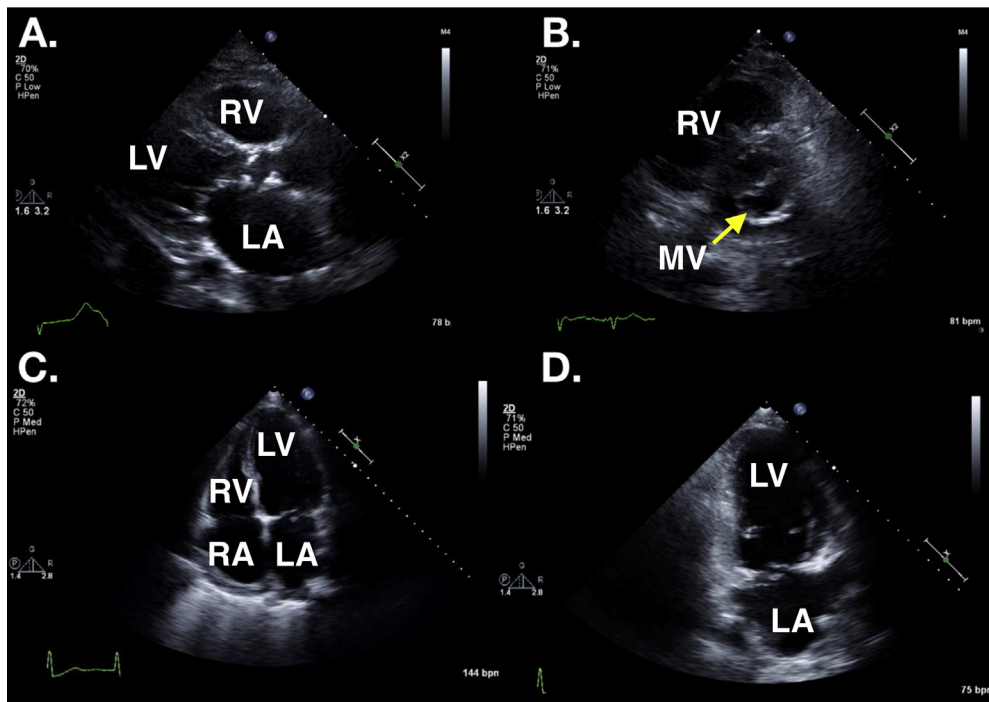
TTE views of the MV. (A) PLAX view provides visualization of the central anterior and posterior leaflet (A2/P2); for medial (A3/P3) and lateral (A1/P1) visualization the probe can be tilted toward the tricuspid valve and aortic valves, respectively. (B) PSAX view of the MV provides the characteristic “fish mouth” view of the MV and will allow for the origin of the MR jet to be determined and for planimetry of MVA (yellow arrow). (C) Apical four-chamber view allows for chamber quantification, both qualitative and quantitative assessment, of the MR as well as measurements of transvalvular gradients. (D) Apical two-chamber view of the MV allows for interrogation of the line of coaptation. RA, Right atrium; RV, right ventricle. (See associated Video 1, available at www.onlinejase.com.)
